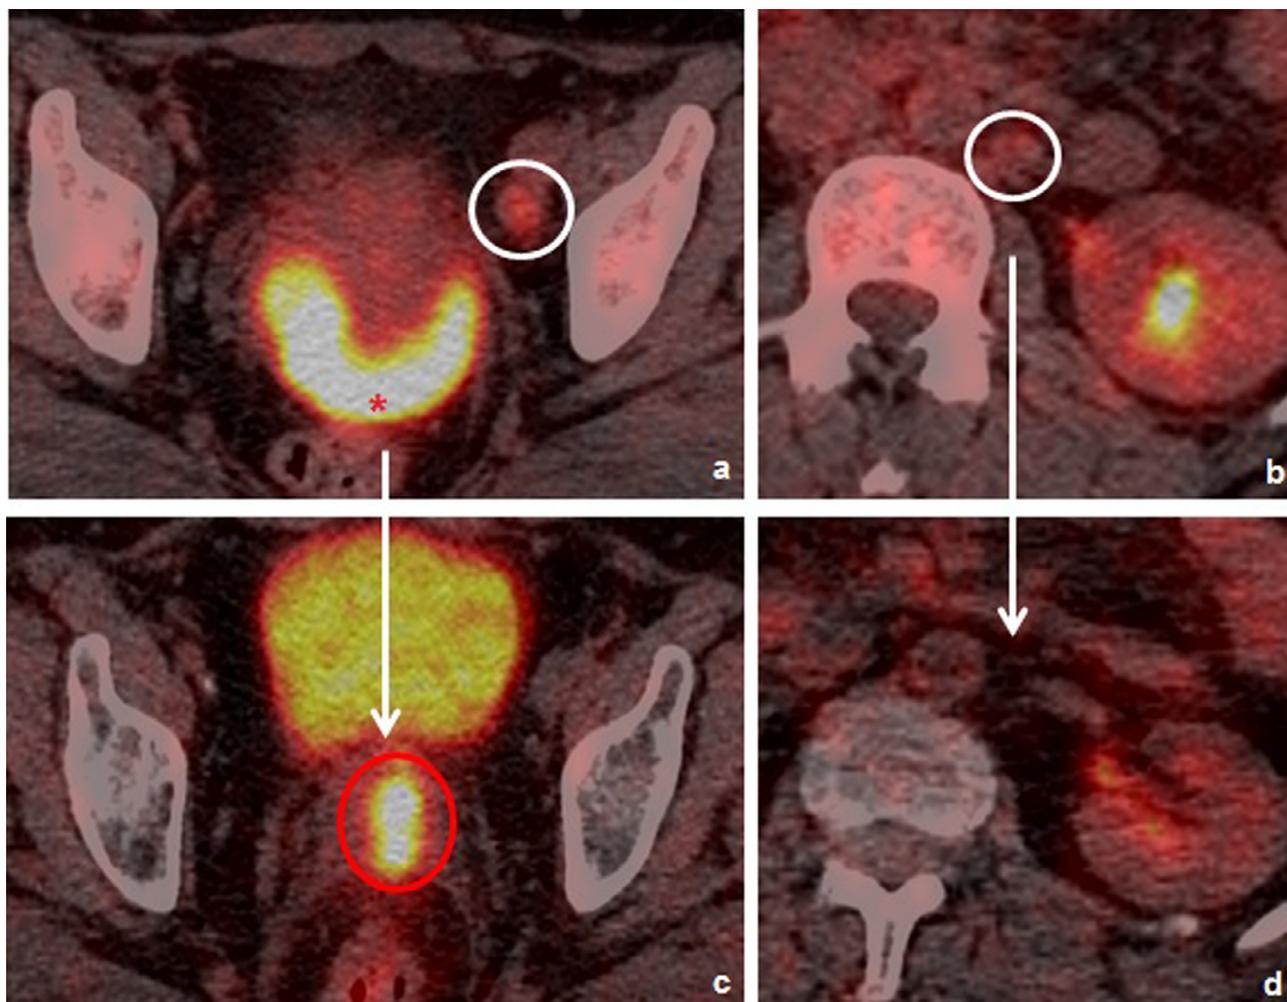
Recurrence post chemoradiotherapy – for consideration of exenteration: 52-year-old (stage IIa) T2 N1 M1 cervical carcinoma (*) with suspicious pelvic and para-aortic nodes (white circles) on staging FDG PET/CT (a,b). The patient underwent chemoradiotherapy including the pelvic and aortic strip + brachytherapy and the 3 month follow-up MRI study (not shown) demonstrated only a small volume of residual signal abnormality within the cervix. A subsequent FDG PET/CT performed 6 months following treatment (c,d) demonstrates local recurrence within the cervix (red circle) but resolution of the pelvic and para-aortic nodal disease with no evidence of metastases. The patient underwent subsequent pelvic exenteration.
